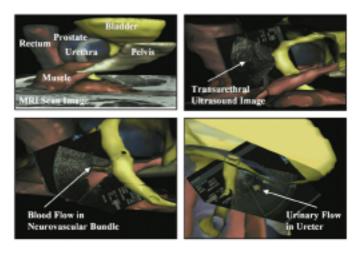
TUUS images registered to segmented and rendered 3-D model of prostate gland and associated anatomy (top left) computed from 3-D MRI scans. Boundaries of the prostate capsule (top right), blood flow in neurovascular bundles (bottom left, using color flow Doppler), and urinary flow in ureter (bottom right) can be visualized in real time during a procedure.
